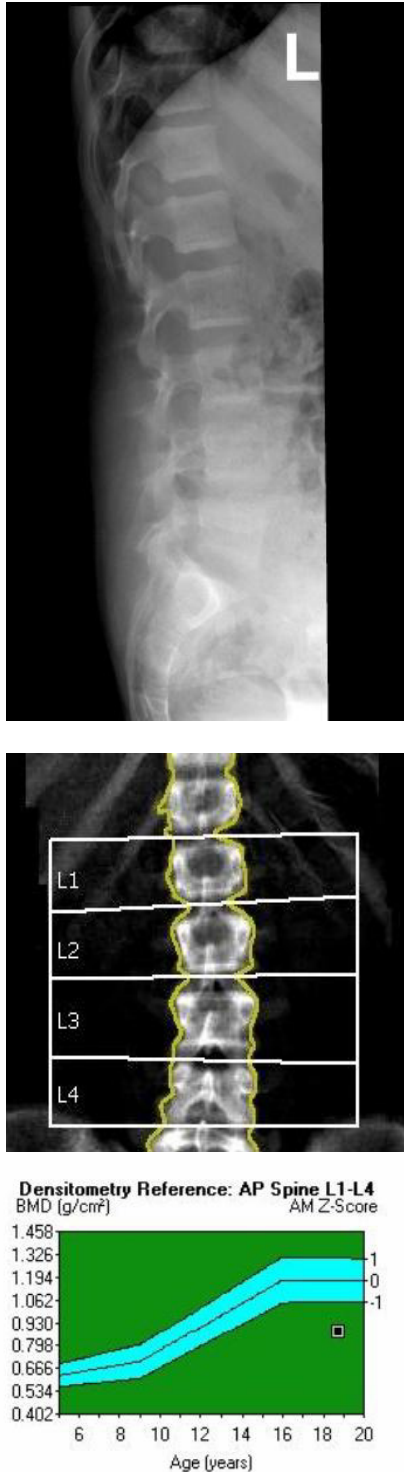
Lateral radiograph lumbar spine showing increased radiolucency of vertebra L1 – L4 with slightly radiodense endplates. DXA scan AP view lumbar spine showing BMD of 0.877 g/cm² with estimated Z-Score of -2.5 indicating established osteoporosis.
